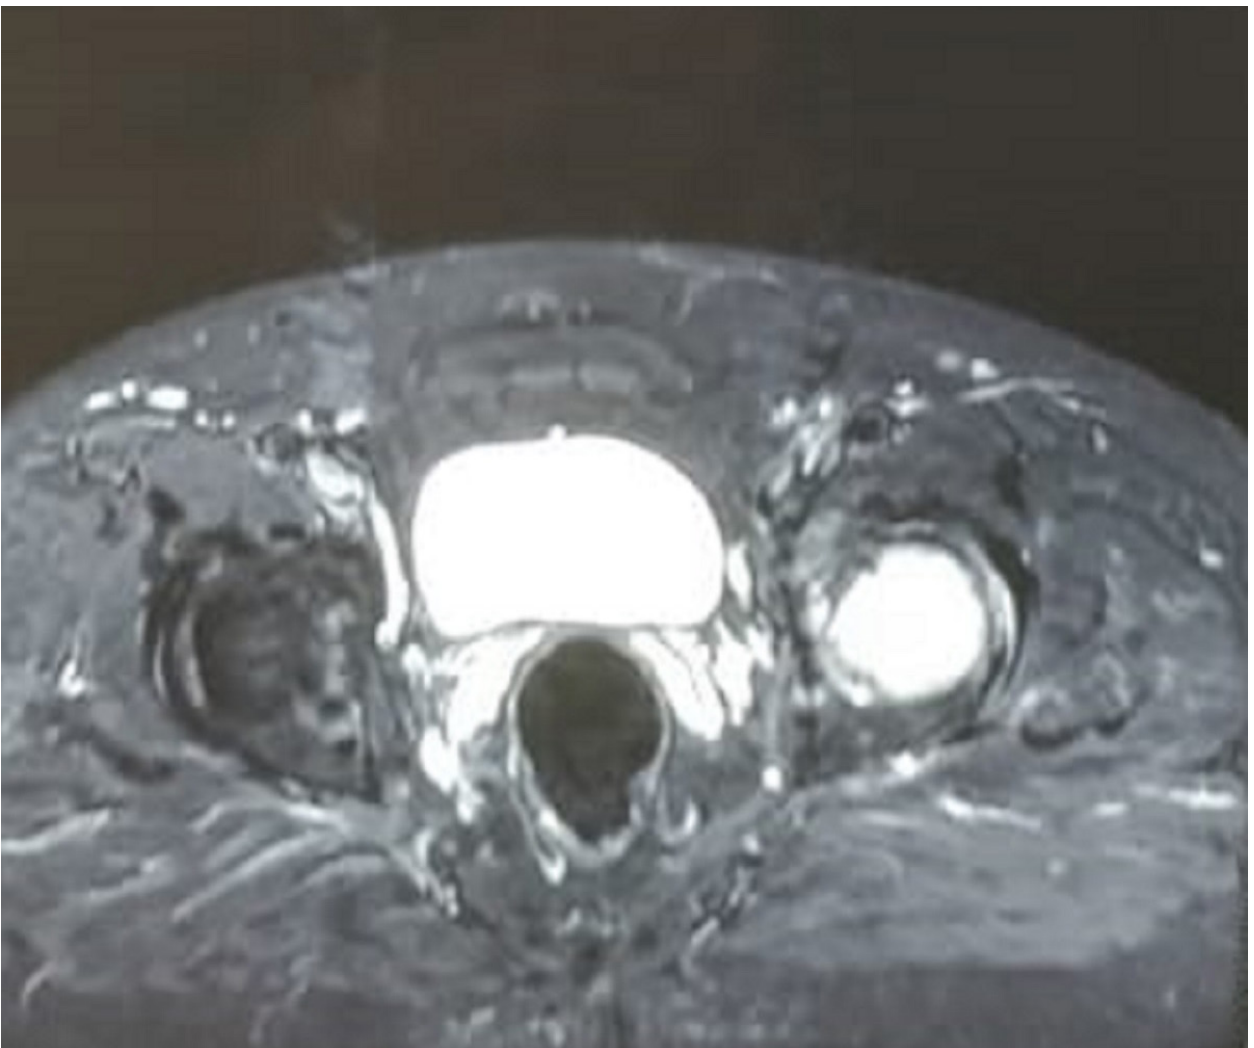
Transverse MRI image showing a hyperintense lesion in the head, the neck of the left hip
